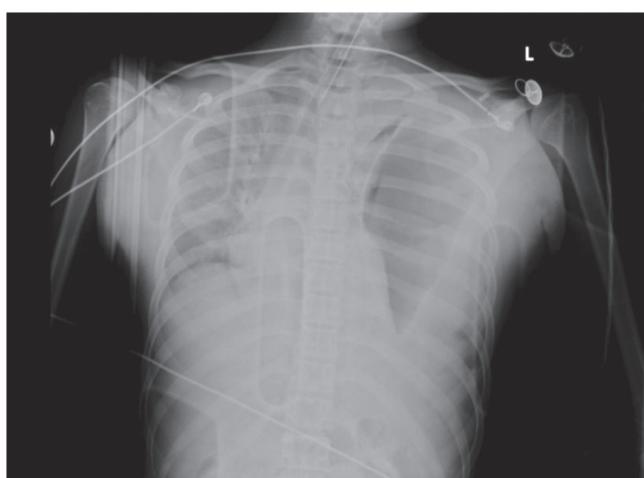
chest radiography shows large air-containing mass in left thorax, loss of lung marking and diaphragmatic outline with mediastinum shift to the right. Initial diagnosis was tension pneumothorax.
